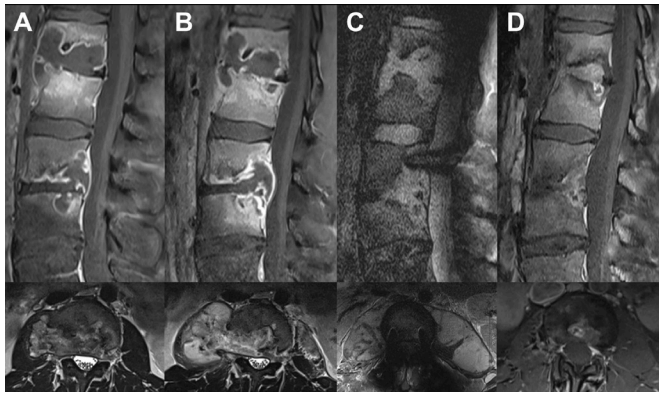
MR images in the sagittal and axial plane at four different time points. (A) Spondylodiscitis with paravertebral abscess invading the right psoas muscle. (B) Progression of the abscess involving the entire cross section of the right psoas muscle. (C) Postoperative images showing extensive bilateral psoas abscesses. (D) Fibrotic/scar tissue with calcifications after completed treatment.
